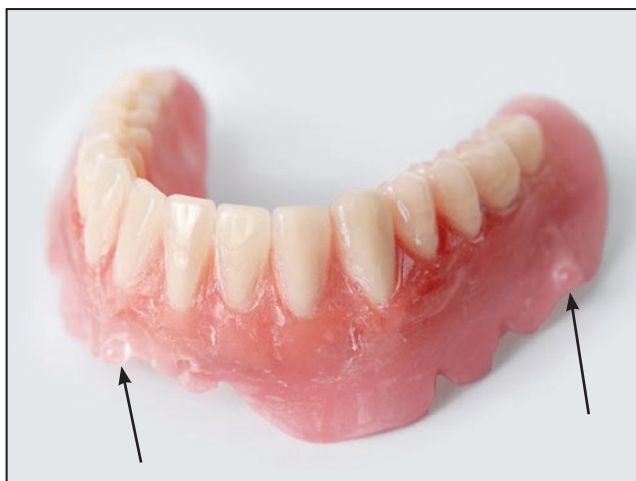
After the first scan (described in Fig 6), the radiopaque beads are integrated into the denture (arrows). This denture will be inserted in the patient's mouth to be used and therefore scanned during the CBCT.
